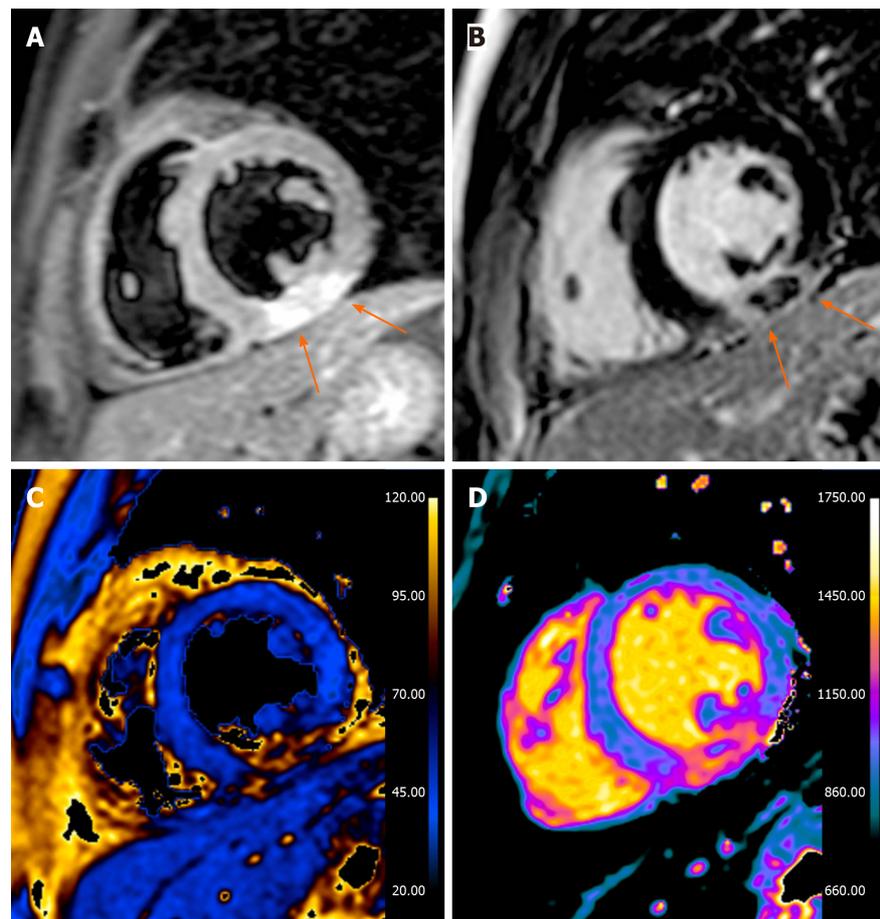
Thirty-three years old male presented with acute chest pain, nonspecific short-tau wave abnormalities, increased troponin values and negative invasive coronary angiography. A: Short axis T2-weighted short-tau inversion recovery image, a transmural hyperintense areas with central hypointensity is seen in the inferior wall (arrows); B: Late gadolinium enhancement image: the hypointense areas correspond with areas of microvascular obstruction and is thought to represent myocardial hemorrhage (arrows); C: T2 map; D: T1 map. The cardiovascular magnetic resonance study is in accordance with acute myocardial infarction with sign of microvascular obstruction and hemorrhage.
